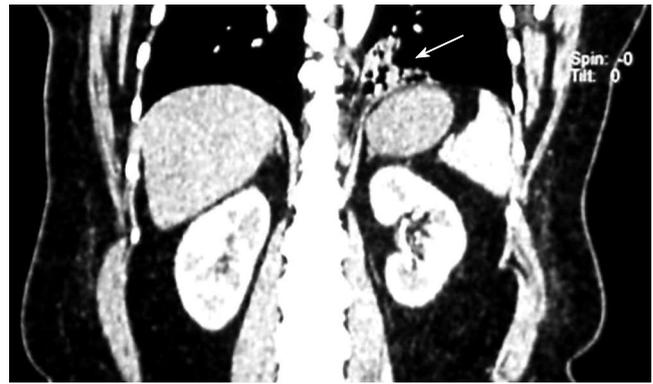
Coronary CT plate showing the pulmonary sequestration of the basal segment of the left lower lobe (arrow).
